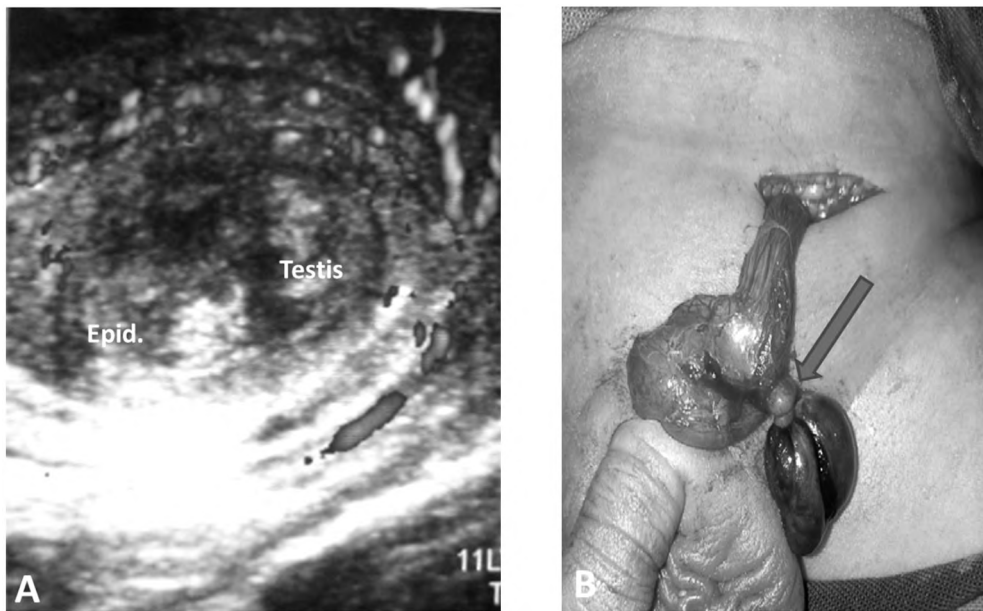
Acute testicular torsion in a boy. (A) Color Doppler image demonstrates no evidence vascularity in the epididymis or testicle. (B) Surgical photo documented the site of the torsion (arrow).
